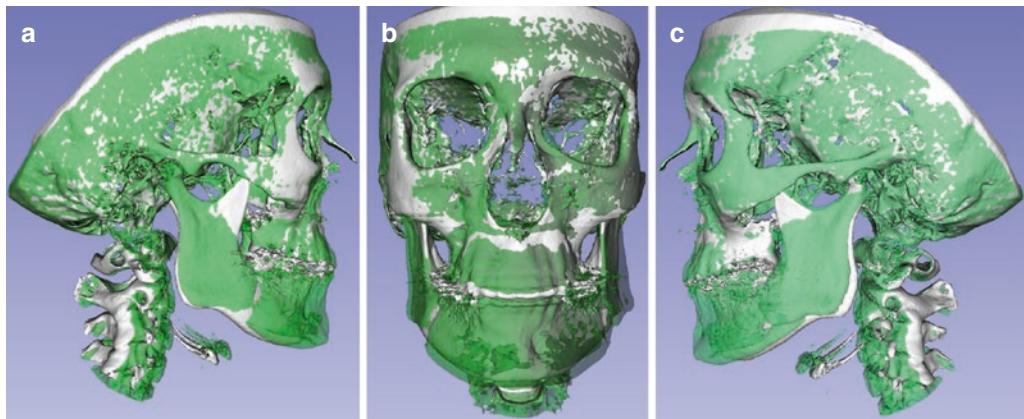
CBCT superimposition of the same patient showing the presurgical surface in white and the postsurgical surface in semitransparent green color, showing the changes after mandibular advancement and maxillary rotation
